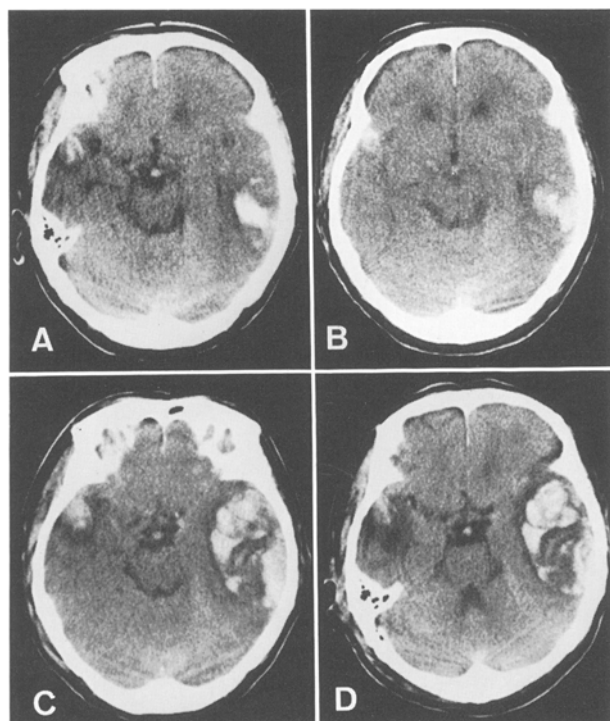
Typical case of gradually growing TIH (Case No. 44). A) CT taken about 1 hour after the fall from 3 m in height shows small haematomas in bilateral temporal lobes. B) CT taken 4 hours after the accident shows almost the same findings as the previous CT. C) CT taken 12 hours after the accident shows the large TIH in the left temporal region. D) CT taken 24 hours after the accident shows the same findings as the previous CT
